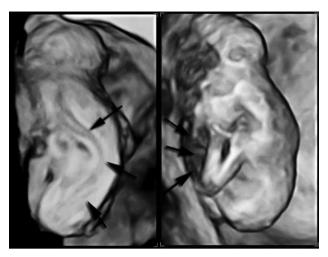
3D ultrasound showing severe scoliosis of the spine with a large defect of the anterior abdominal wall.
